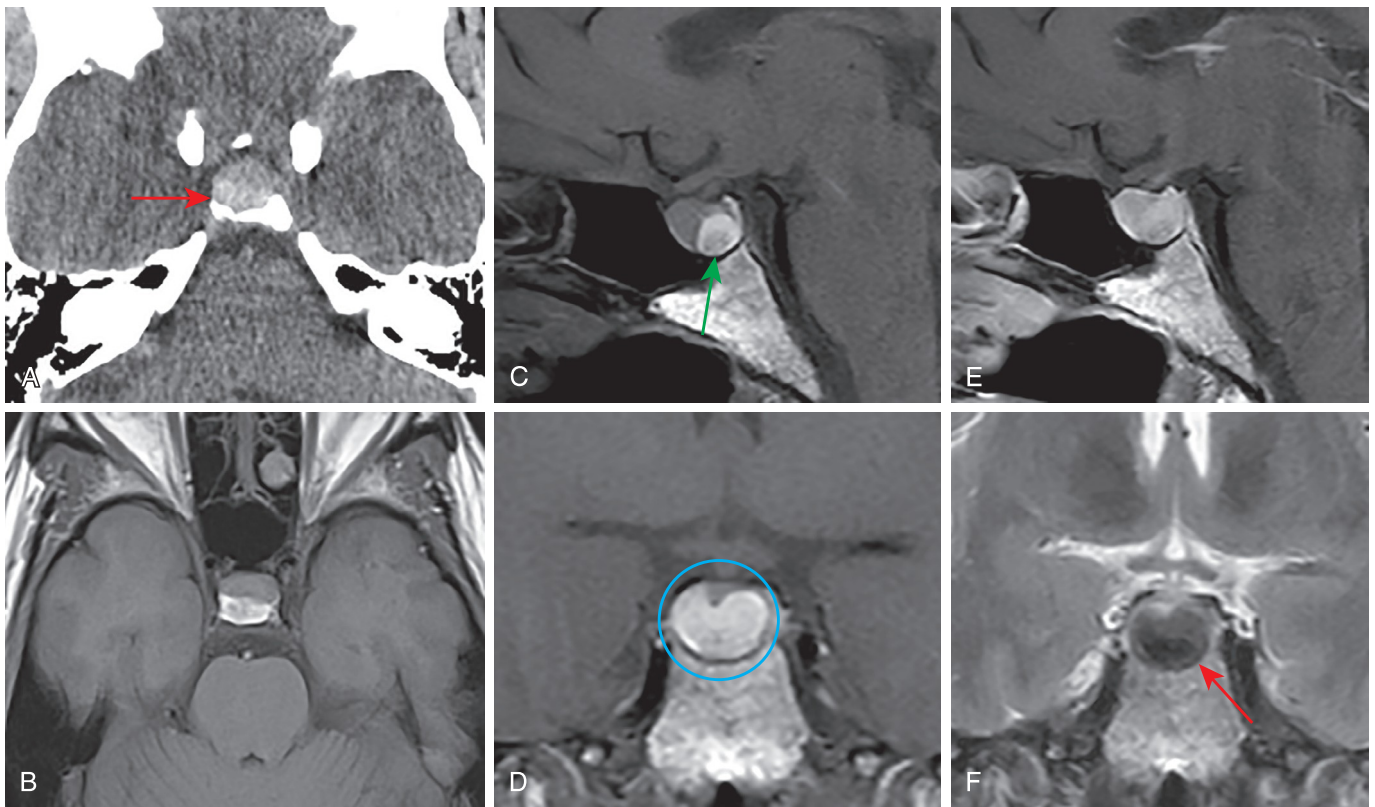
Rathke's cleft cyst. A 48-year-old woman with headache. (A) Hyperdense lesion within the middle and posterior pituitary gland (*red arrow*). (B–D) Precontrast axial, sagittal, and coronal T1 magnetic resonance imaging (MRI) demonstrates a T1 hyperintense lesion within the middle and posterior sella. (The lesion is too large to represent the normal neurohypophysis—the posterior pituitary bright spot.) (E) Postcontrast sagittal MRI T1 demonstrates normal enhancement of the adenohypophysis (anterior pituitary gland). (F) Coronal T2 demonstrates hypointense region corresponding to area of T1 hyperintensity in D (*blue circle*), consistent with a high-protein-content cyst. Hypointense intracystic nodule typical of Rathke cleft cyst is also identified on multiple sequences (*green arrow* in C) and (*red arrow* in F). The intracystic nodule is felt to represent a concretion of protein within the proteinaceous cyst. (This lesion did not change over 3 years of follow-up.)
